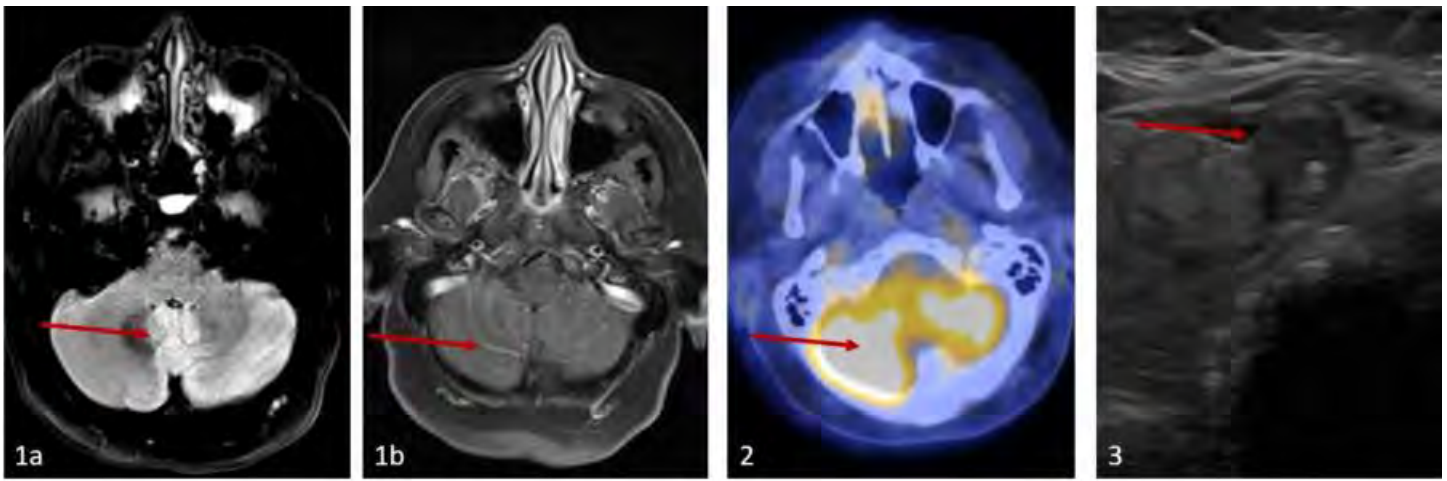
Axial FLAIR image of brain demonstrates signal abnormality involving the cerebellum and vermis (1a) with diffuse leptomeningeal enhancement on post Gad axial T1-W image(1b).
